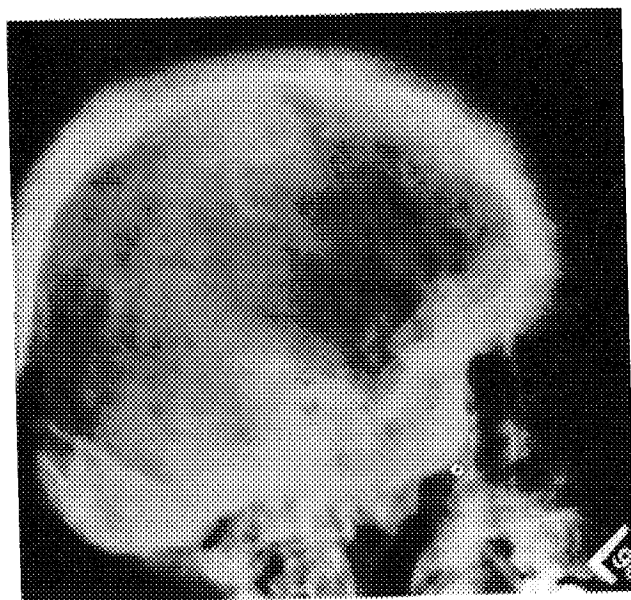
Skull radiograph showing extensive involvement of the cranium with polyostotic fibrous dysplasia and distortion of the sellar region.
